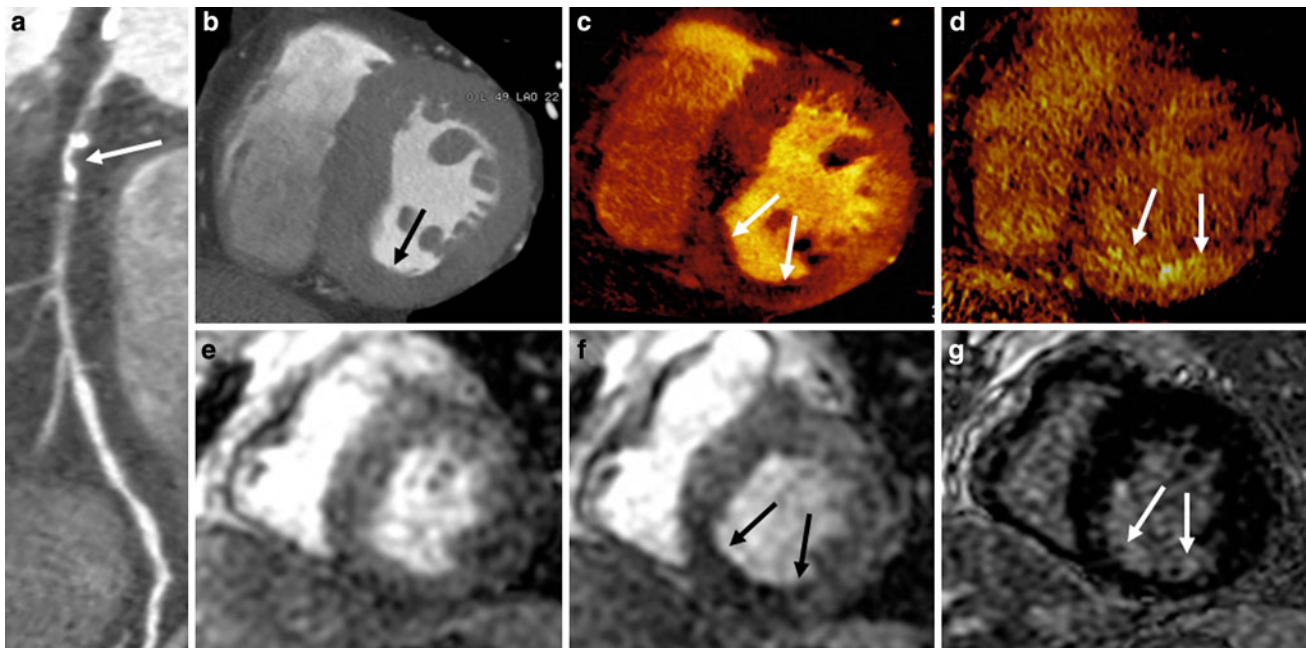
Example of stress DECT perfusion for stent evaluation. Curved multiplanar reformatted coronary CT angiographic image (a) shows significant stenosis with mixed calcified and non-calcified plaques (arrow) in the ostium of the left circumflex artery (LCx). Conventional coronary angiogram finding (b) confirms the presence of significant stenosis (arrow) in LCx ostium. DECT-based iodine distribution mapping during adenosine infusion (c) reveals concentric blood pool deficits (arrows) in the mid LV myocardium. The patient
